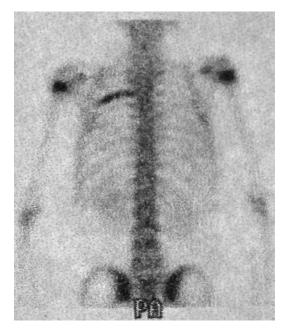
Osteomyelitis in a 7 year-old X-linked CGD patient. Total body scintigram showing a posterior arch left rib fungal oeteomyelitis in a CGD patient. His only manifestation was increased erythrocyte sedimentation rate in a routine follow up laboratory control. No fever, pain or discomfort was reported at presentation
